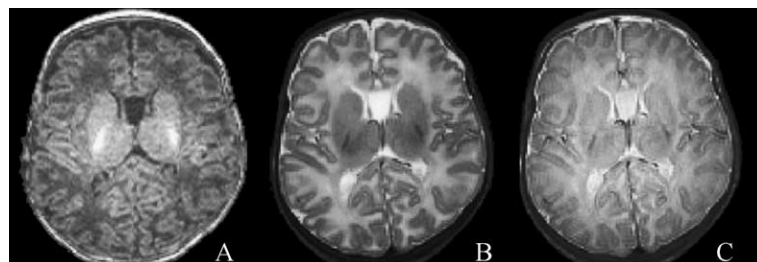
T1-weighted (A), T2-weighted (B), and proton density weighted (C) axial images of a neonate. Note the reversed intensity of white and gray matter in the T1-weighted image (A); white matter in the neonate is heterogeneous as well, with hyperintensity of central myelinated white matter. The T2 weighted image (B) shows hypointensity of central myelinated white matter, hyperintensity of cerebrospinal fluid, and excellent contrast between white matter and cortical and subcortical gray matter. Also note large cavum septum pellucidum in this child.
